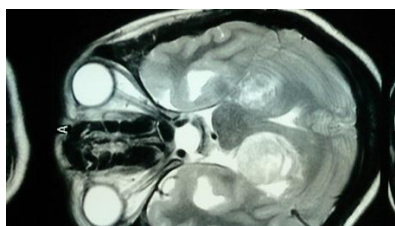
MRI brain in coronal view showing tumour at cerebello-pontine angle).
